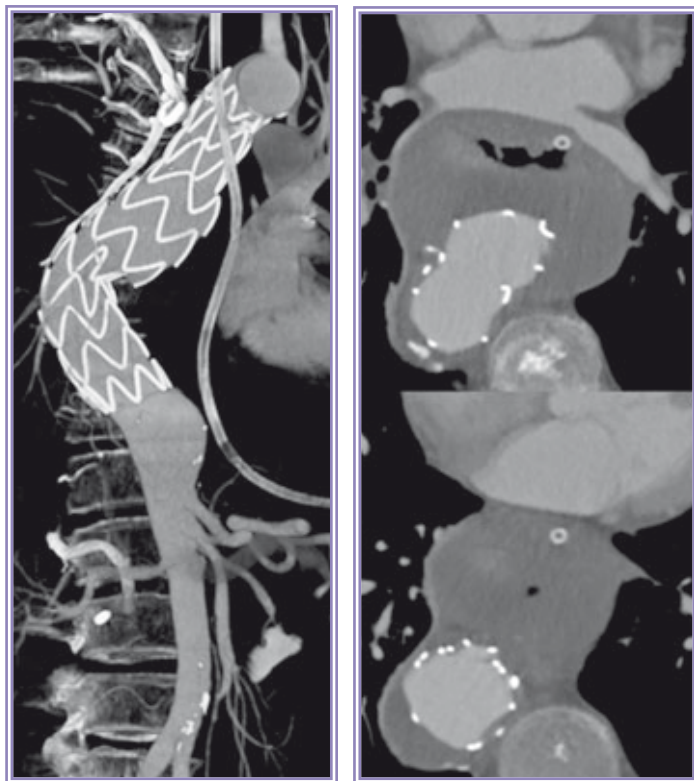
CT scan showing the aneurysm sac in contact with the esophagus at the level of the previously deployed TEVAR, and the presence of periaortic air collection.
